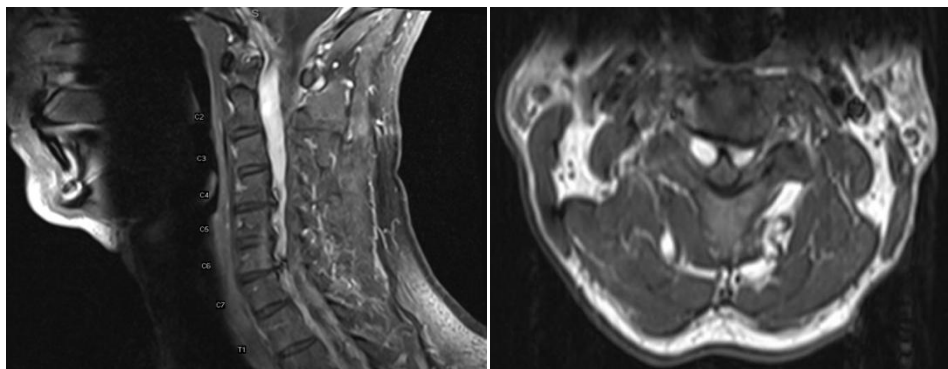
Preop MRI of the cervical spine with contrast. On the left is a sagittal cut showing the ventral enhancing cystic pocket extending from C2 to C6. On the right image the ventrally located venous engorgement is noted bilaterally, causing central canal stenosis.
